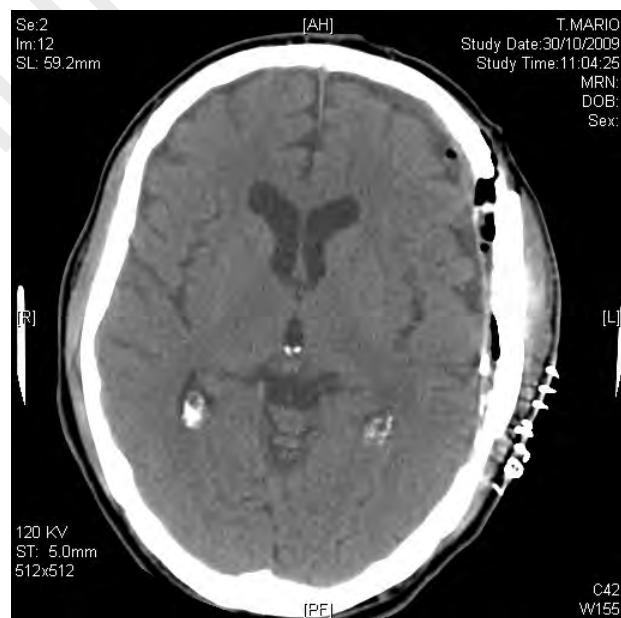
Case 5. Post-craniotomy computed tomography shows the disappearance of the lesion.
